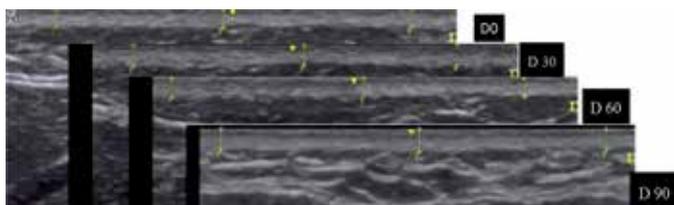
Ultrasound images of the submental region captured at the different experimental occasions D0 (first visit), D30 (30-days visit), D60 (60-days visit), and D90 (90-days visit). The dermal area is delimited between the yellow markings, in the upper portion of each image
